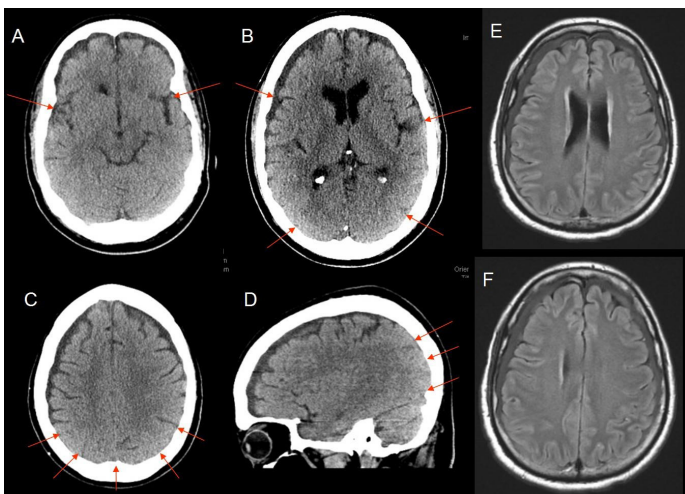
Non-contrast axial (A,B,C) and sagittal (D) computerized tomography of the head in the acute stage of the illness showing the presence of bifrontal hygromas and the sulcal effacements of the parieto-occipital lobes (arrows) as an effect of gravity in the critically ill patient lying supine. The axial Fluid Attenuated Inversion Recovery (FLAIR) MRI sequences (E,F) demonstrated the bifrontal fluid collection with signal characteristics consistent with blood containing hygromas. The frontal lobes show pseudoatrophy while in the parieto-occipital regions there is effacement of the cortical sulci.
